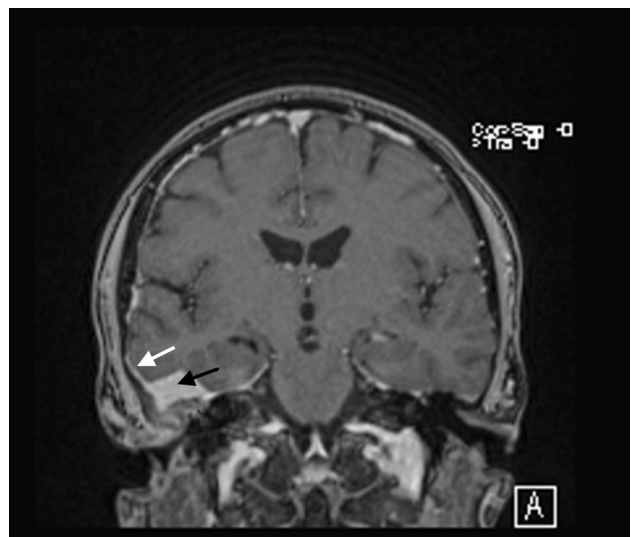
Magnetic resonance imaging, multiplanar reconstruction-coronal contrast-enhanced T1 GRE MR scan. A homogeneously enhanced tumor (black arrow) invading temporal bone is present. Moreover, flat reinforcement of the surrounding dura mater, so-called “dural tail sign” is evident (white arrow)
